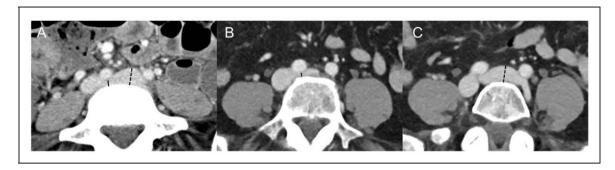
Stenosis measurements, including lesion lumen diameter (solid line), and reference lumen diameter (dashed line) on CT studies utilizing: single slice method (a), multiple slice method at site of compression and in normal vessel lumen peripherally (b, c).
